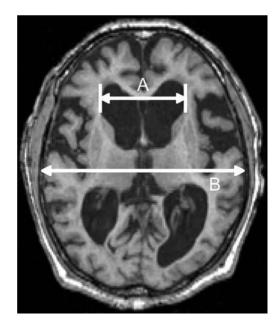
Head MRI. Evans ratio is calculated as the ratio of the widest diameter of the frontal horns (A) to the widest diameter of the brain (B) on the same axial slice³³
